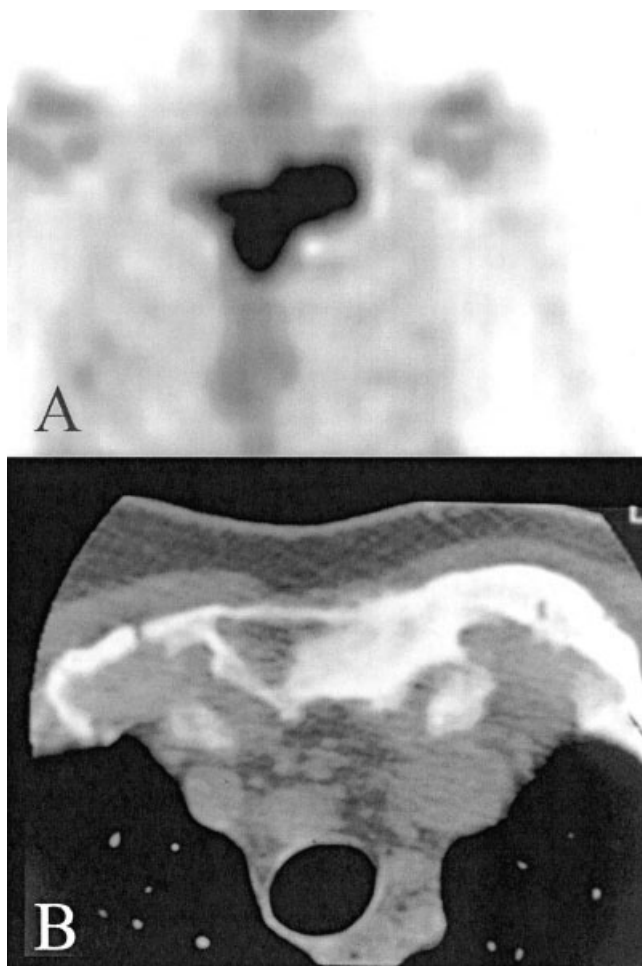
A, Skeletal scintigraphy and B, computed tomography (CT) images of the sternocostoclavicular hyperostosis (SCCH) patient shown in Figure 1. Note the characteristic (half) bull head appearance of the scintigram due to increased uptake in the sternum and the medial end of the left clavicle, with corresponding sclerosis and hyperostosis on the CT image.
